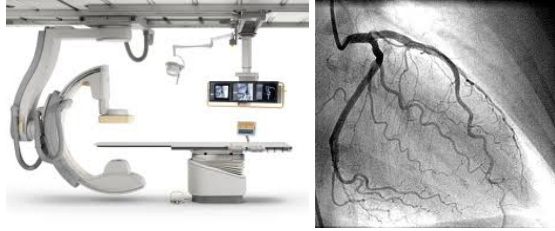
(top) is a representation of the catheterization lab with the X-ray tube used for making cineloop movies and the imaging software that allows real time or reviewing of the movies. (bottom) conventional angiogram of coronary arteries of the heart (colored black)
